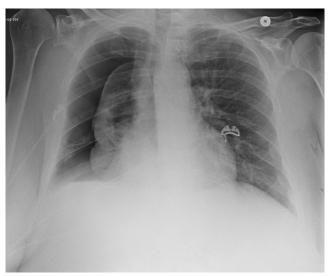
Classic radiographic finding of a pneumothorax showing a thin visceral pleural line lying parallel to the chest wall, separated by a radiolucent band devoid of lung markings.
